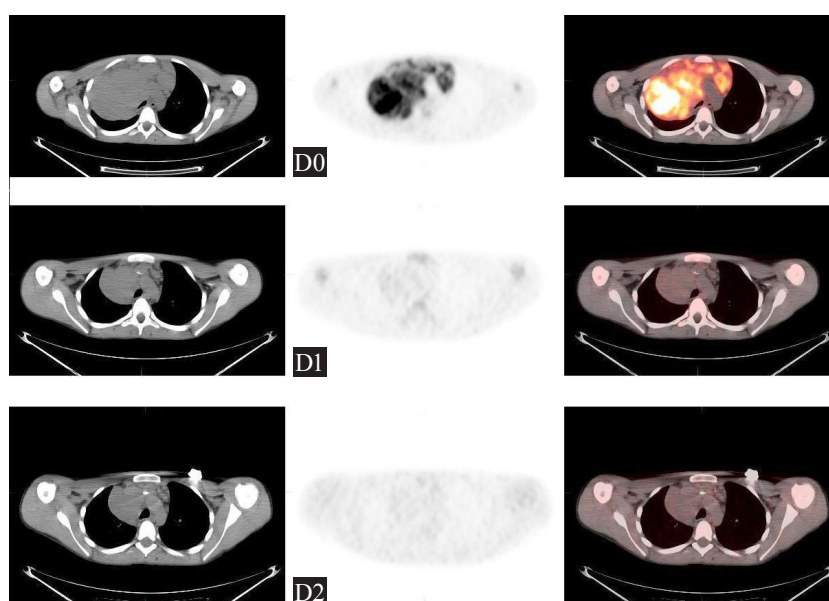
Example of good response to treatment. D0 demonstrated disease involving mediastinum. D1 and D2 demonstrated residual mass on CT scan, but not metabolic active on the ^{18}F -FDG PET images.
